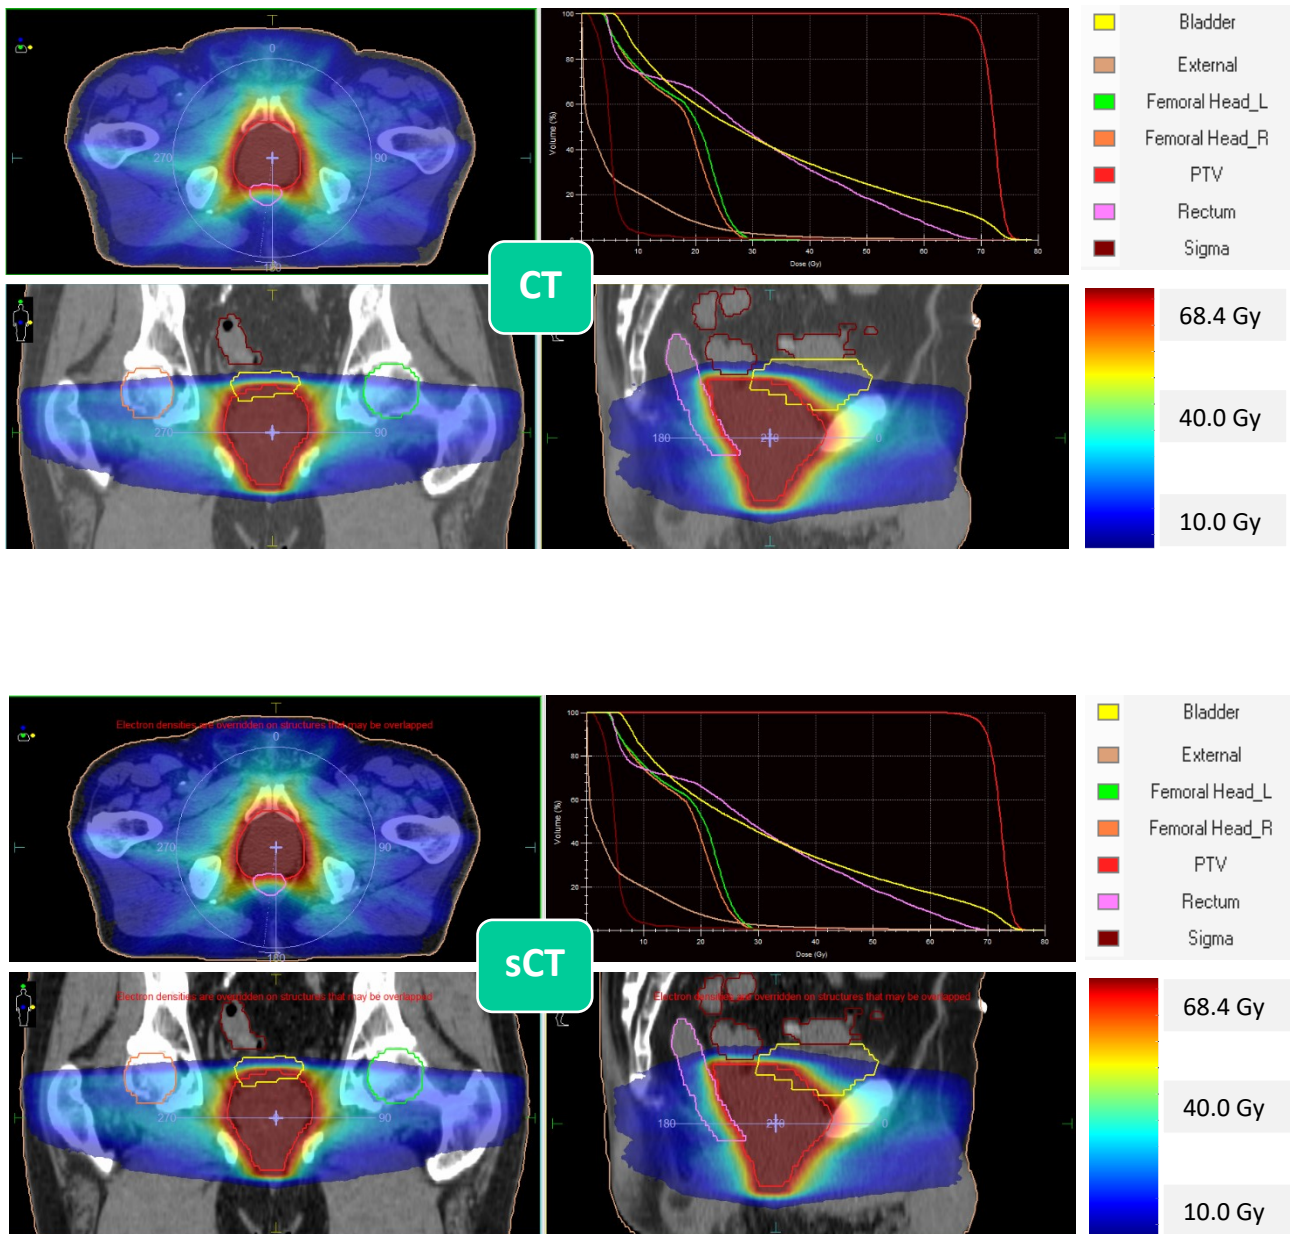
Example of CT-based plan (top) and sCT-based one (bottom), in which a fixed ED was assigned for each structure.
